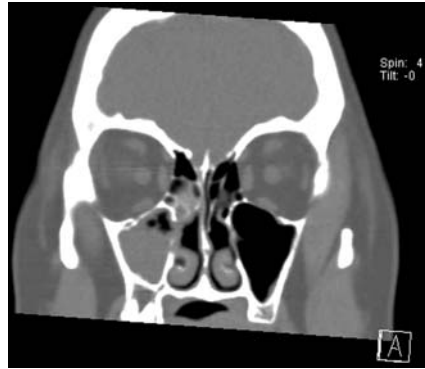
Coronal CT demonstrating acute on chronic rhinosinusitis with complete opacification of bilateral ethmoid sinuses, left maxillary sinus mucosal thickening, and air bubbles within the right maxillary sinus indicating purulence
